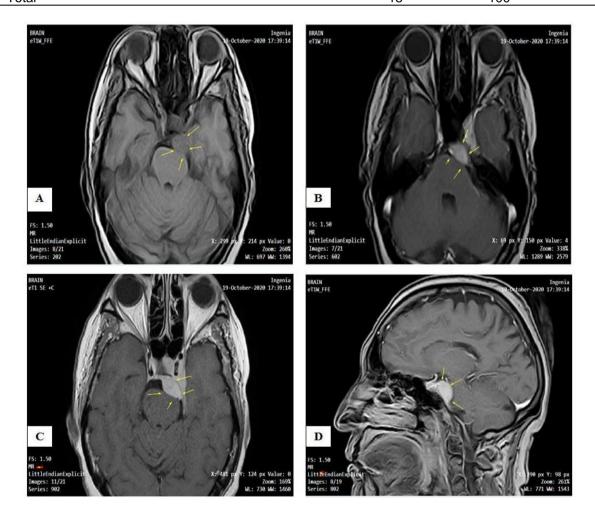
Female patient 64 years old, presented by left sided trigeminal neuralgia. MRI brain revealed: (A) axial T1WI, (B)axial FLAIR WI and (C & D) axial and sagittal T1WI post contrast revealed a small well defined extra axial petrous apex space occupying lesion (Mass) seen in the left prepontine cistern and supra-sellar cistern measures about 2.1x1cm exhibits intermediate T1 and T2 signal intensities with intense homogeneous contrast enhancement with enhancing dural tail along the dorsum sellae. It exerts mild mass effect in the form of mild compression of the left side of the pons. It is more to be consistent with extra axial SOL (left petrous apex meningioma)
